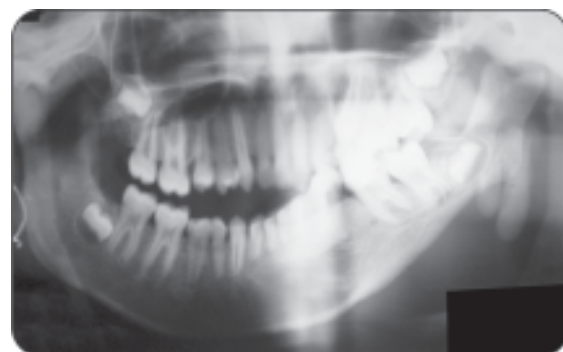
Radiograph of hemifacial microstomia
